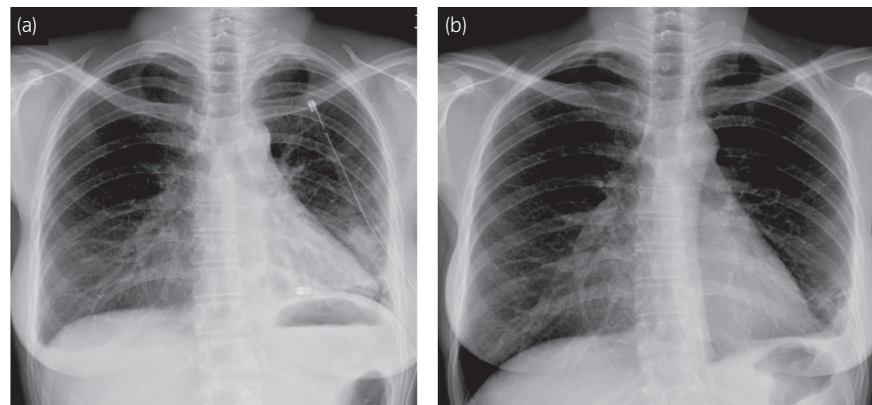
Chest X-ray performed following VATD showing pleural collection on the left side. (a) One day after VATD, pleural collection had resolved. (b) After discharge, the left lung showed complete expansion.
